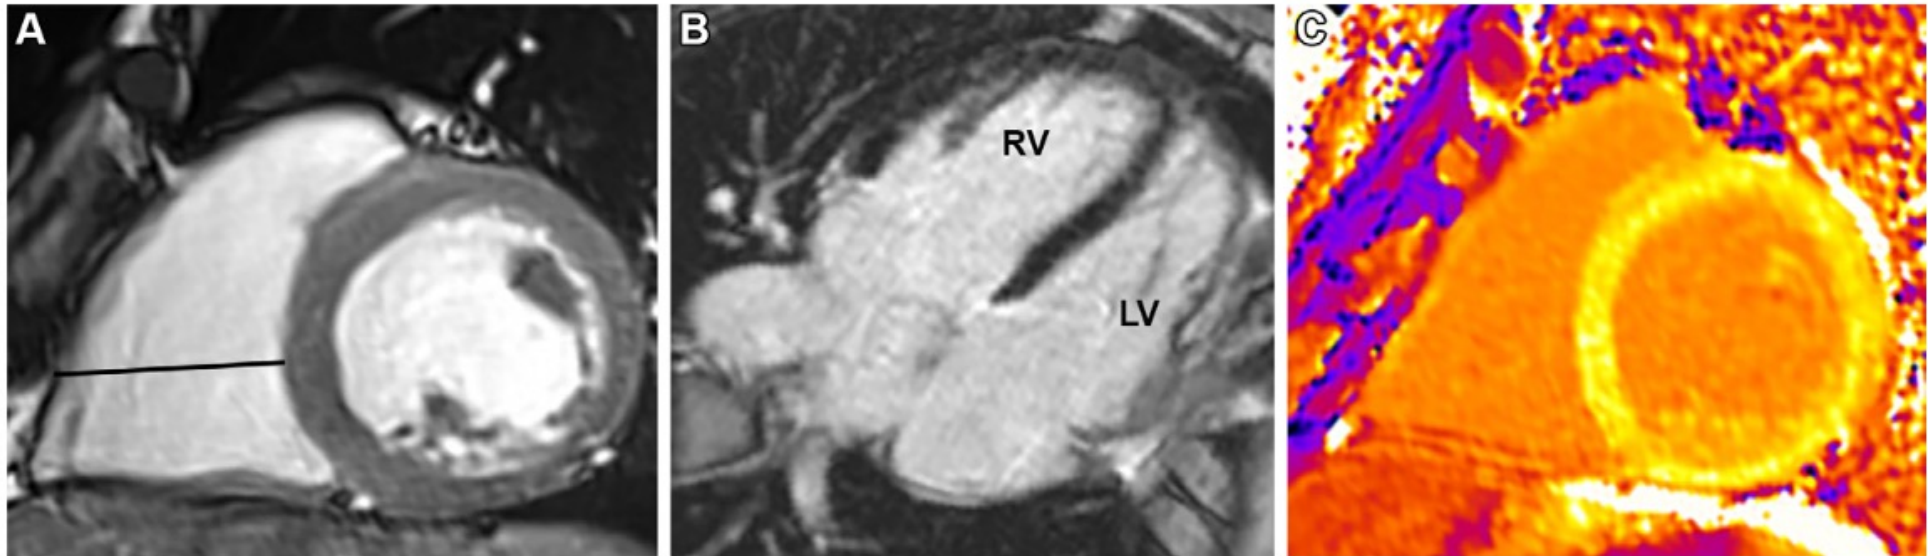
Athlete's heart (dilated RV phenotype) in a 51-year-old male competitive marathon runner with echocardiographic findings suspicious for dilated cardiomyopathy. (A) Short-axis cine SSFP image shows dilatation of the RV with an end-diastolic diameter of 52 mm (black line) and EDVi of 111 mL/m² (normal, <105 mL/m²) with normal ejection fraction. The LV is normal in size (EDVi, 110 mL/m²) with normal ejection fraction. (B) Four-chamber PSIR image shows a dilated RV. No abnormal LGE was seen in the LV or RV. (C) Short-axis T1 map shows normal T1 values. ECV was slightly reduced to 21%, which is typical for athletes. With this constellation of findings, athlete's heart was diagnosed.
